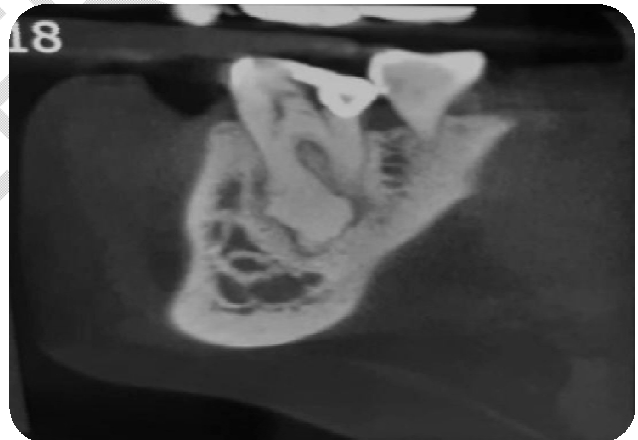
CBCT Imaging of 36
